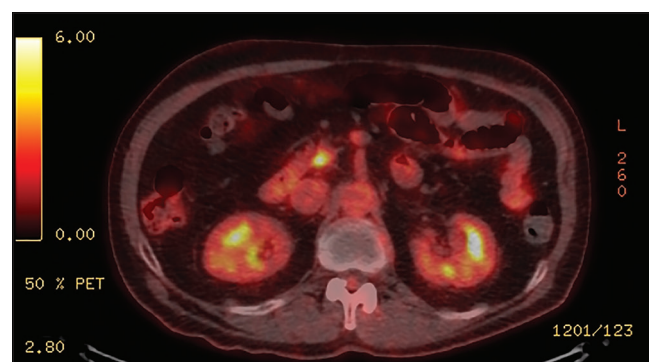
FDG-avid lesion in the head of the pancreas
